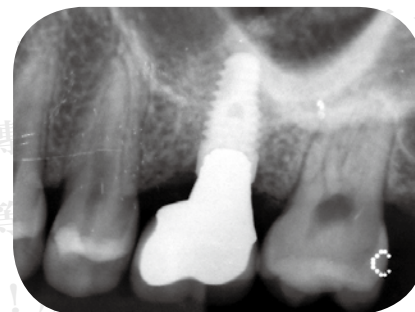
Radiograph of the new implant-supported prosthesis.
